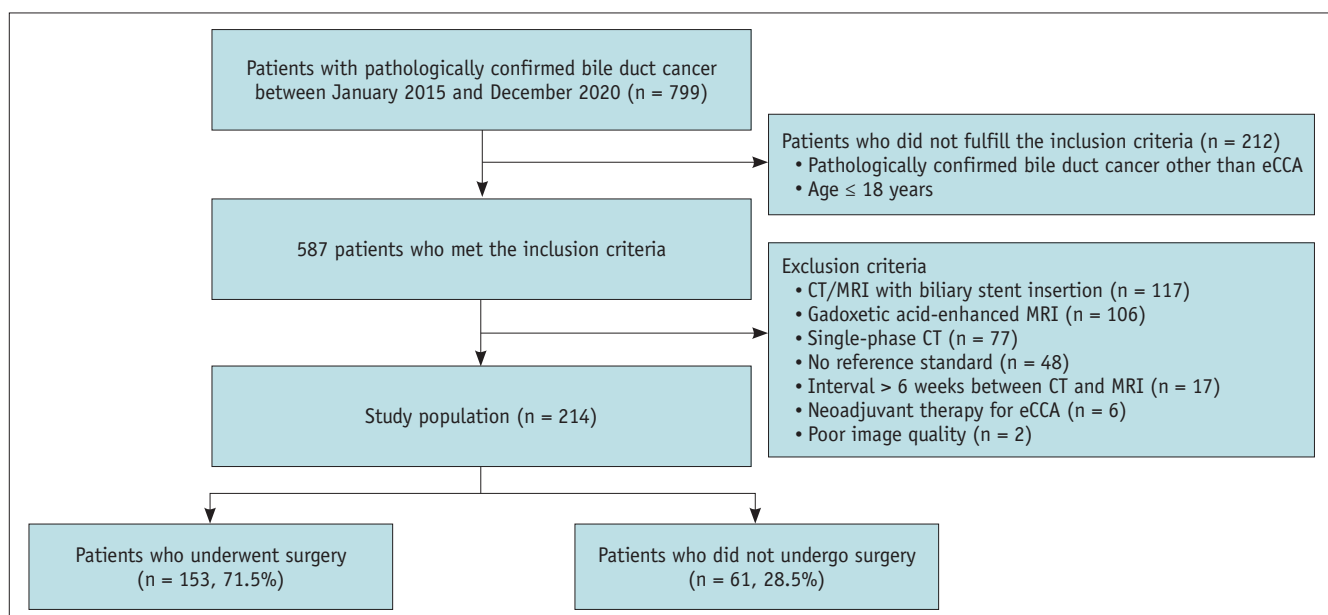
Study flow. The final study population included 214 treatment-naïve patients with pathologically confirmed eCCA, who underwent both CECT and CE-MRI with MRCP using extracellular contrast media between January 2015 and December 2020. eCCA = extrahepatic cholangiocarcinoma, MRI = magnetic resonance imaging, CT = computed tomography, CECT = contrast-enhanced computed tomography, CE-MRI = contrast-enhanced magnetic resonance imaging, MRCP = magnetic resonance cholangiopancreatography
